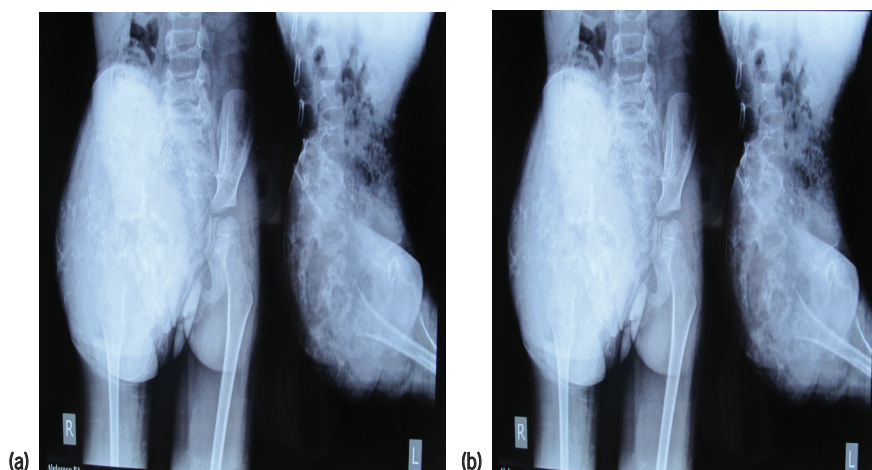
Pelvic X-ray showing a malignant chondroid lesion of the right ischium with the possible involvement of the right femoral head (AP and lateral) (a and b). Axial CT scan showed suggestive a sarcoma on the pelvis (c)
